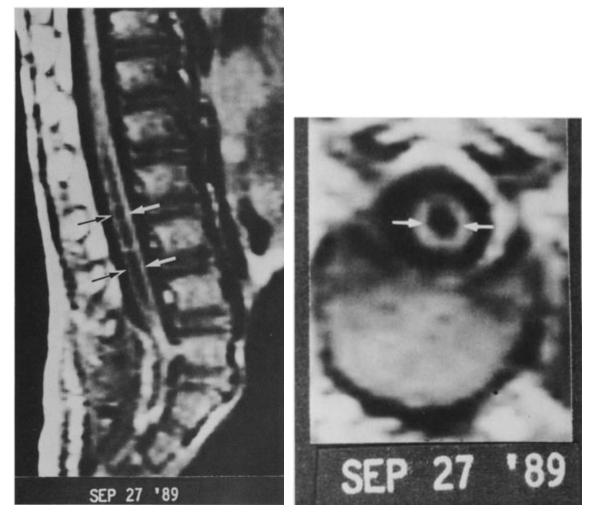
shows an MRI scan taken 9 days after the fatty lump inside the spine was removed through surgery. It's still a T1-weighted MRI, with a side view (sagittal) on the left and a front view (coronal) on the right. In this scan, you can see that the pocket of fluid called syringomyelia has shrunk a lot (indicated by arrows).
